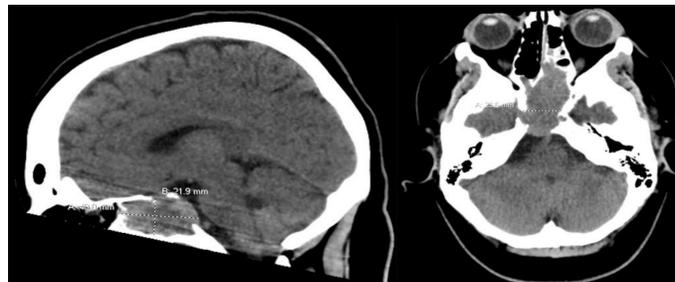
CT Head: Large mass filling and expanding the sphenoid sinuses with invasion into the adjacent sella, posterior ethmoid sinuses, and clivus.
